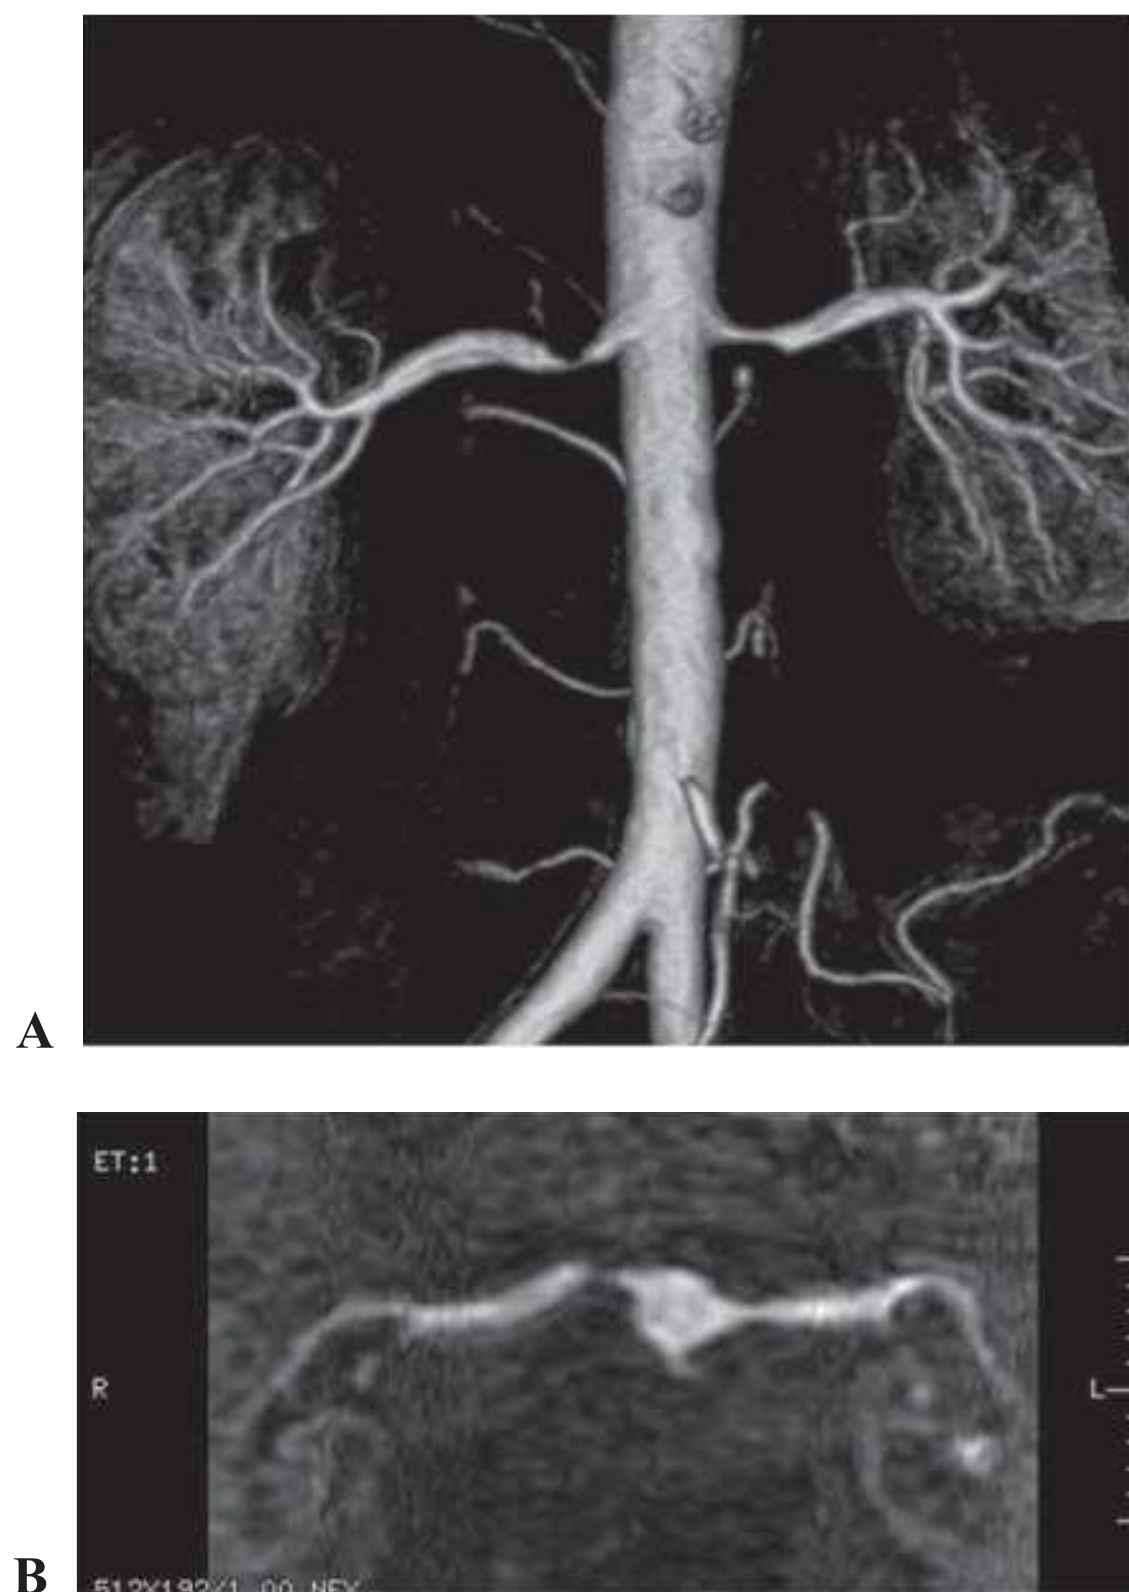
Examples of magnetic resonance angiograms (MRAs) with (A) vascular reconstruction using gadolinium contrast. Continually improving MR imaging allows for the definition of smaller vessels with improved resolution and the definition of parenchyma without ionizing radiation. Use of gadolinium-based contrast agents has declined after concerns about nephrogenic systemic fibrosis (NSF) in patients with impaired glomerular filtration rates (GFRs). B: Time-of-flight imaging without contrast in the axial plane also can provide excellent definition of vascular occlusion, even at oblique angles from the aorta.
